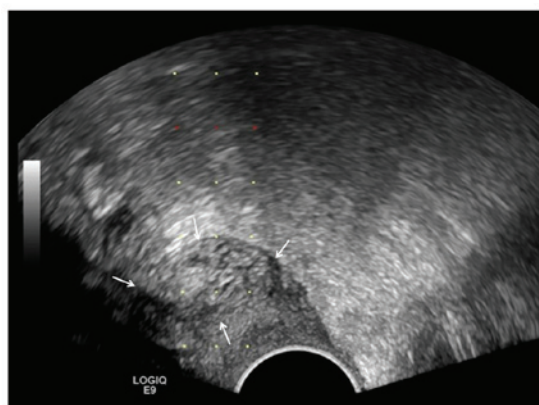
TVUS of a 67/F patient with endometrial cancer. Biopsy was taken at the vaginal stump, with a mass of 3.0x1.7 cm, indicated by the white arrows. TVUS, transvaginal ultrasound.
